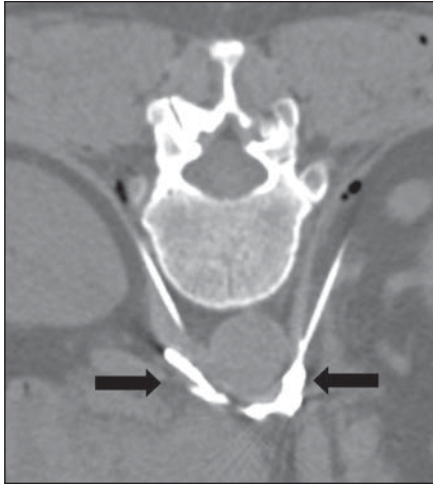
Celiac plexus neurolysis in 65-year-old woman with pancreatic cancer. CT of abdomen in prone position after injection shows combination of contrast material and alcohol (arrows) in vicinity of celiac plexus along lateral aspect of aorta.
